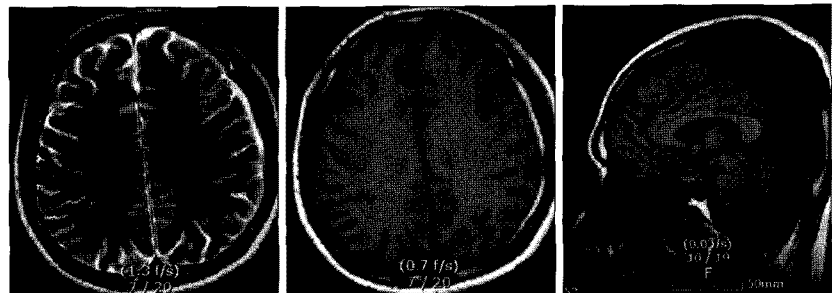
A 3-month follow-up MRI of brain shows complete resolution of the retroclival extradural hematoma.
